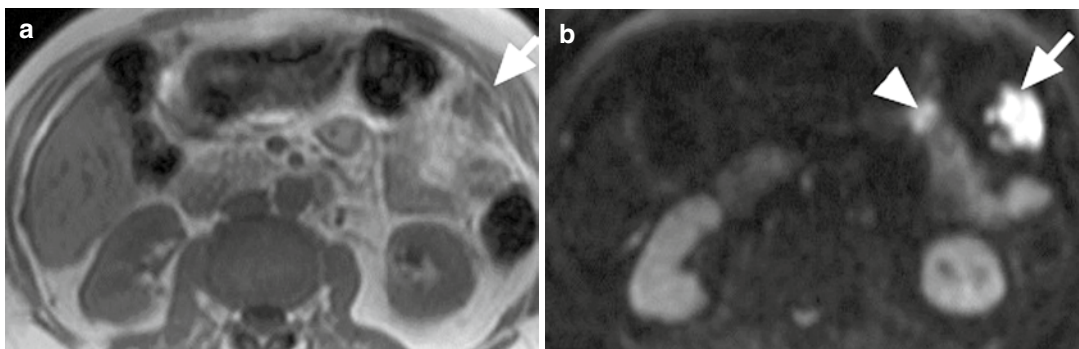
Peritoneal disease. (a) On the T1-weighted image, the peritoneal disease in the left flank is more difficult to discern (arrow) compared with (b) the $b=900 \text{ s/mm}^2$ image, where the lesion appears markedly
